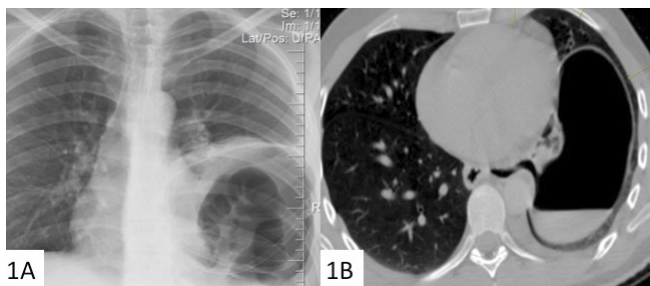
Chest X-ray showing air fluid level
